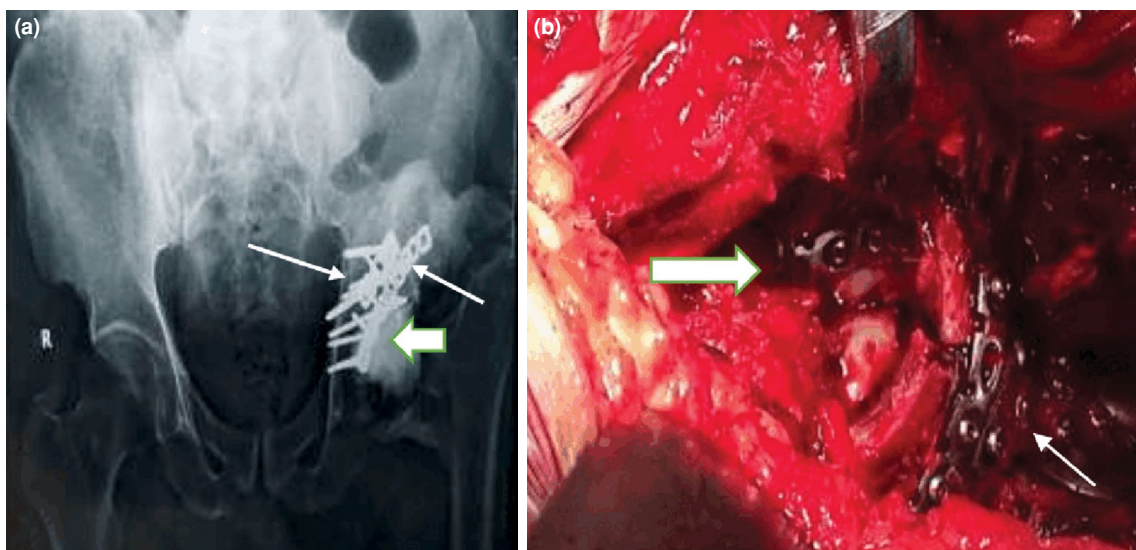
Images of the fixation of the acetabular columns. (a) Postoperative X-ray views after fixation of the acetabular fractures. Thick arrows point to the intra-articular anterior plate and thin arrows to the posterior plates. (b) An intra-operative image showing the 4.5-mm plate for the posterior column (thin arrow) and the 3.5-mm plate for the anterior column (thick arrow).
